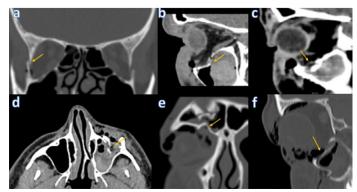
Fracture cases 4a. Coronal CT image presents a fracture in the orbital lateral wall 4b-f. Sagittal orbital CT image shows displaced fracture of the orbital inferior wall and air densities 4c-d. 34 years old male bear attack with diffuse displaced fractures to the inferior wall of the orbit, air images and hemosinus 4e. Coronal CT image visualized a displaced fracture in the upper wall of the orbit
